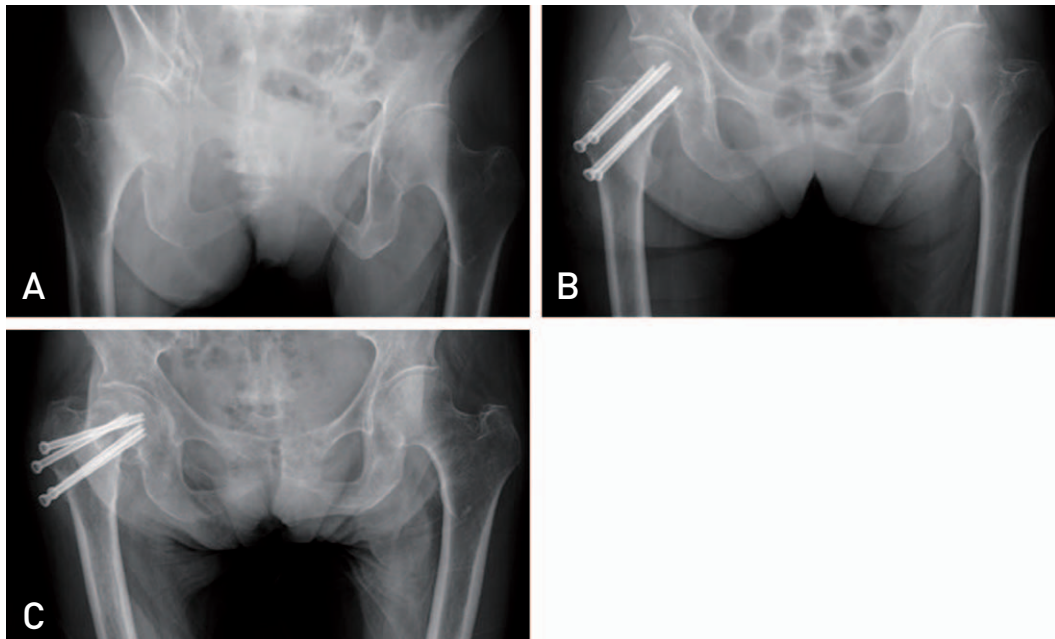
Eighty two year-old female patient with valgus impacted right femoral neck fracture. (A) Preoperative plain film shows valgus impacted neck fracture in the right femur. (B) *In situ* internal fixation with 4 cannulated screws. (C) Six weeks after the operation, fixation failure occurred.
